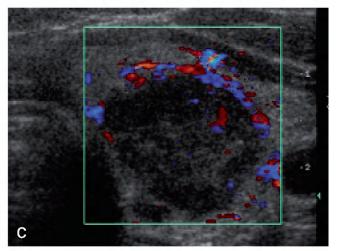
Ultrasound of metastasis in the left lobe (leiomyosarcoma). A and B, Transverse. C, Color Doppler.
